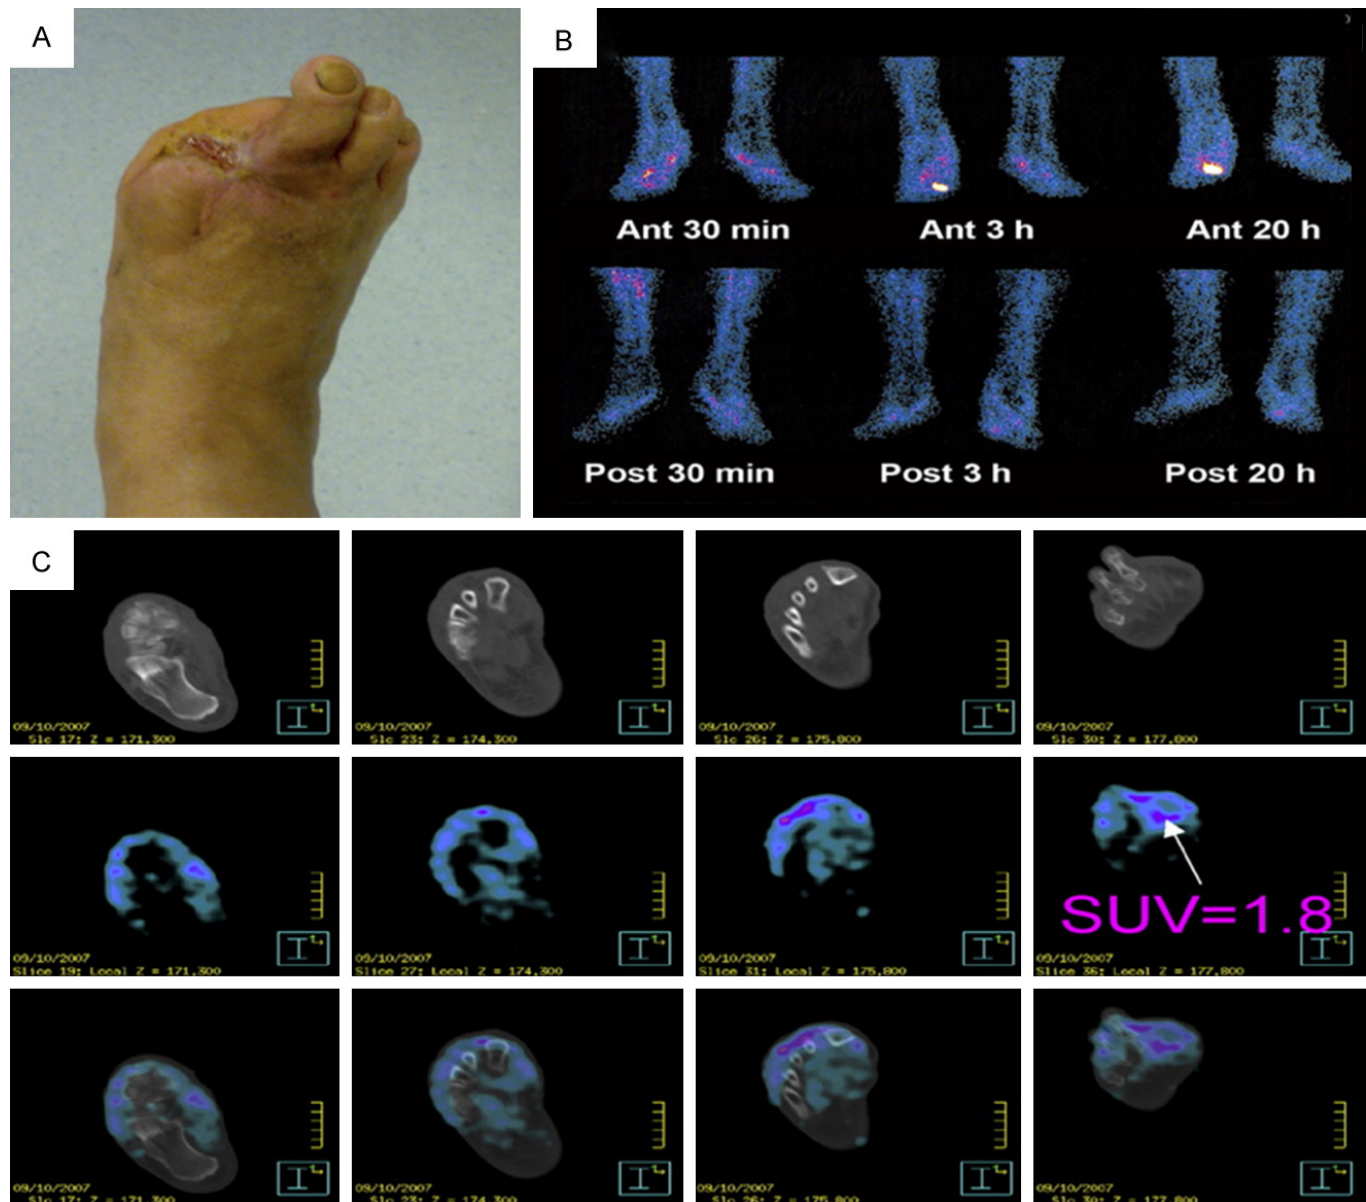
Discordant results in a diabetic foot patient with biopsy-proven osteomyelitis. (A) Clinical image. (B) WBC scintigraphy at 30 min, 3 h, and 20 h shows T/B ratio > 2.0 increasing over time, correctly identifying osteomyelitis. (C) ^{18}F -FDG-PET/CT at 1 h shows $\text{SUV}_{\text{max}} = 1.8$, falsely negative for osteomyelitis. Reproduced from [28] © SNMMI.
